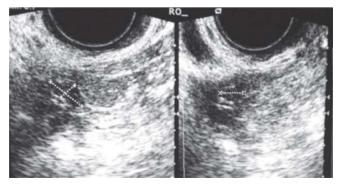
Transvaginal ultrasound showing measurement of the right gonad. The right gonad measured 1.1 cm x 0.7 cm x 0.5 cm. It is devoid of follicles.
